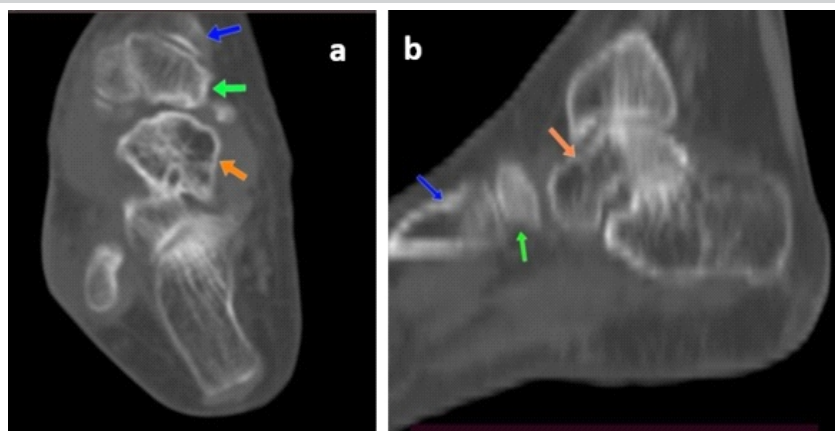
Computed tomography images of the right foot. (a) Axial section and (b) sagittal section demonstrating complete absence of the navicular bone with direct articulation between the talus (orange arrow) and cuneiform (green arrow); first metatarsal bone (blue arrow).
